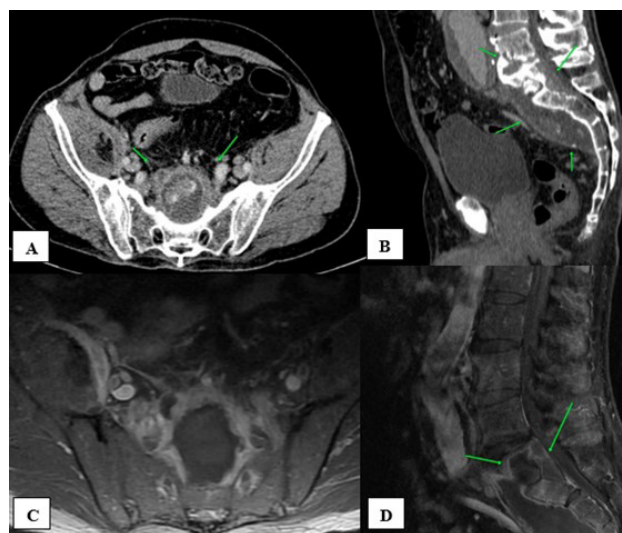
(A-B) axial and sagittal sections of contrast-enhanced CT showing a collection with capsular enhancement with heterogeneous content (pointed by the arrows), anterior to the vertebral bodies of the sacrum, with extension into the spinal canal, associated with erosion of the vertebral body of L5 and, notably, of S1. (C-D) gadolinium-enhanced T1 sequences showing extension of the collection to the right psoas muscle and erosions, sequestration and bone abscess in the vertebral body of S1 (pointed by the arrows).
